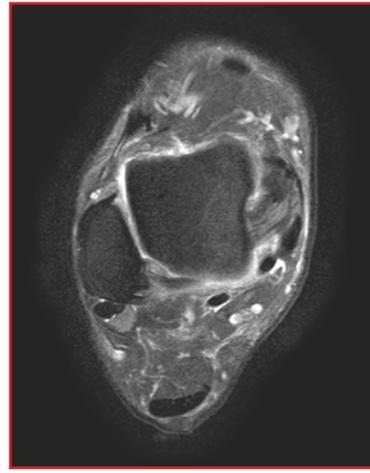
Magnetic resonance imaging in case 2, showing a subcutaneous mass posterior to the Achilles tendon.
